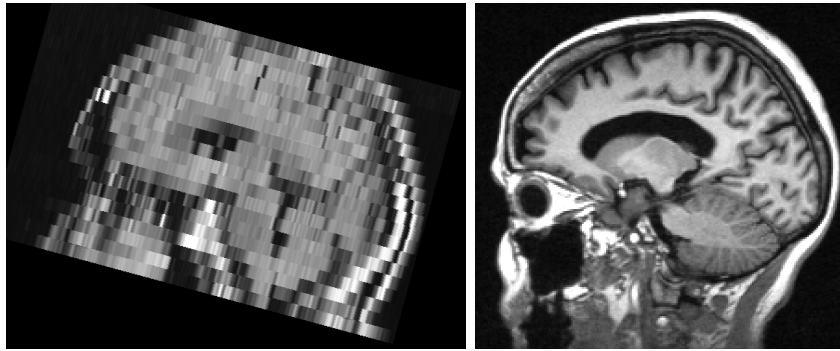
A sagittal slice of a representative low resolution T2-FLAIR scan (left) compared to the sagittal slice of a representative high resolution T1 scan (right). The top of the T2-FLAIR image is cropped, and due to the thick slices, there is no clear intensity boundary between the brain and the skull.
